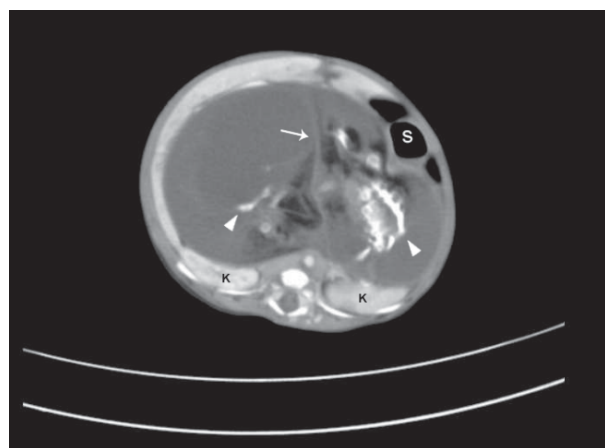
(a) Axial contrast enhanced CT showing a cystic mass divided by a septa (arrow) containing two sets of ossific elements (arrow heads). The mass has pushed the kidneys (K) posteriorly and the stomach (S) anteriorly.
